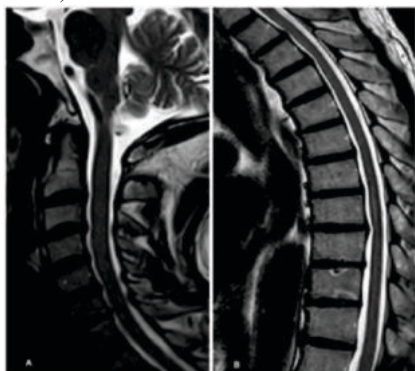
MRI Spine images: T2 sagittal cervical spine(a) and dorsal spine(b) images show normal signal intensity of spinal cord.
